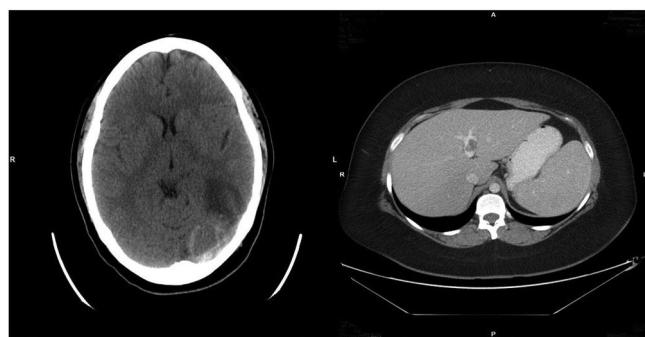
Left. Brain CT shows hyperdensity of the left transverse sinus associated with posterior temporal infarction with haemorrhagic transformation. Right. Abdominal CT reveals a non-occlusive thrombus in the portal vein.
